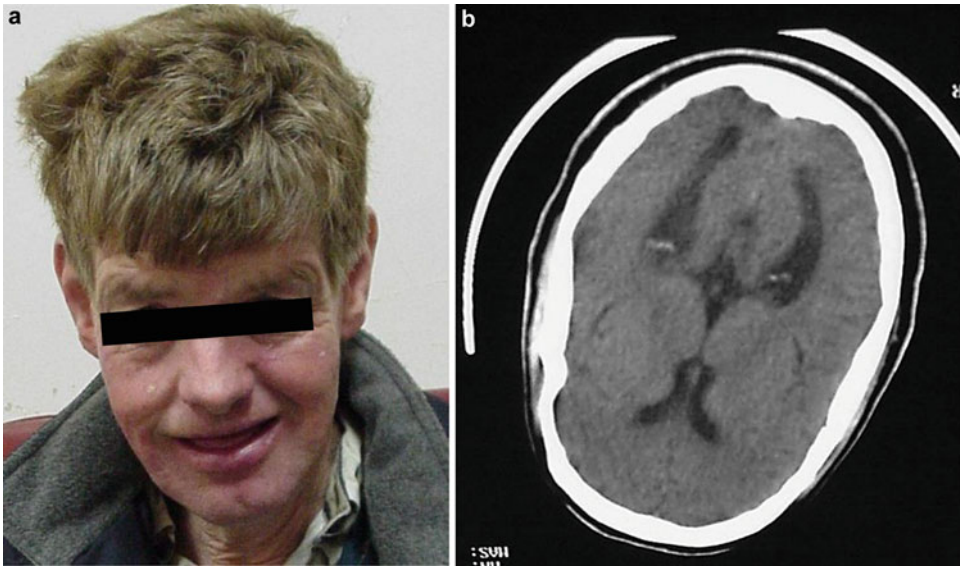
(a, b) An adult with congenital CMV infection showing mental retardation and intracranial calcifications by CT scan
